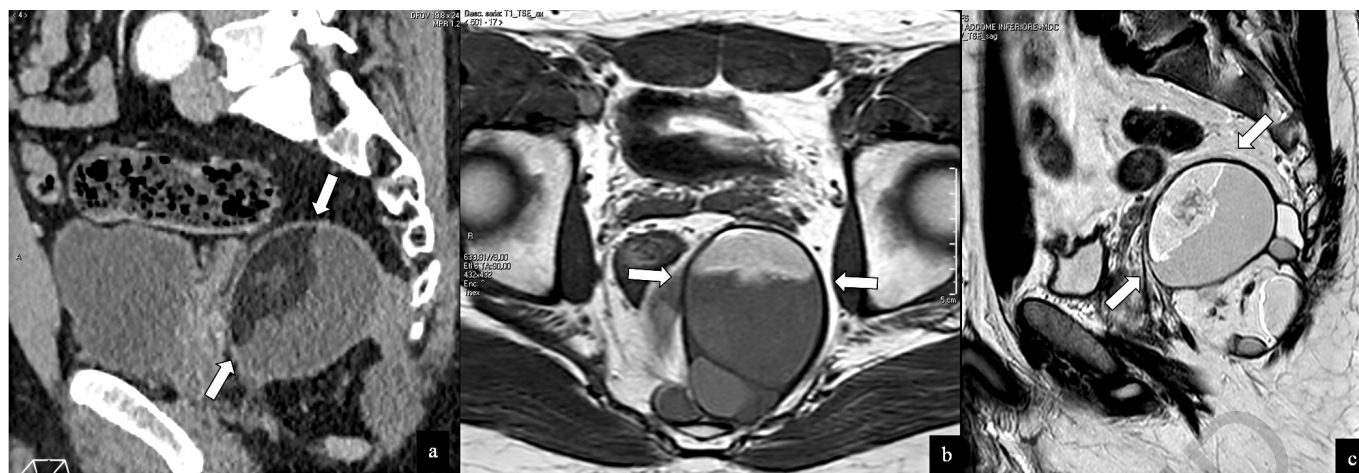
Retroperitoneal mature cystic teratoma. Sagittal multiplanar reconstruction contrast-enhanced CT (a), axial T1-weighted (b), and sagittal T2-weighted (c) MRI images reveal a encapsulated mass in the presacral space with “fat-fluid level” (arrows), a typical sign of cystic teratoma.
